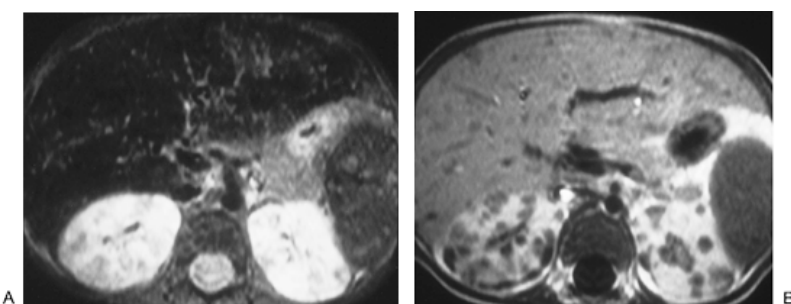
2. Use of gadolinium-enhanced MRI in the presence of renal failure. This patient had been treated for acute myelogenous leukemia and developed fevers. Renal function was significantly diminished (serum creatinine = 2.9 mg/dL). A: Noncontrast T₂-weighted scan demonstrates nonspecific heterogeneous signal within the renal parenchyma. B: Postgadolinium-enhanced MRI demonstrates multiple distinct filling defects in the kidney and liver. These proved to be fungal (*Candida*) abscesses.
